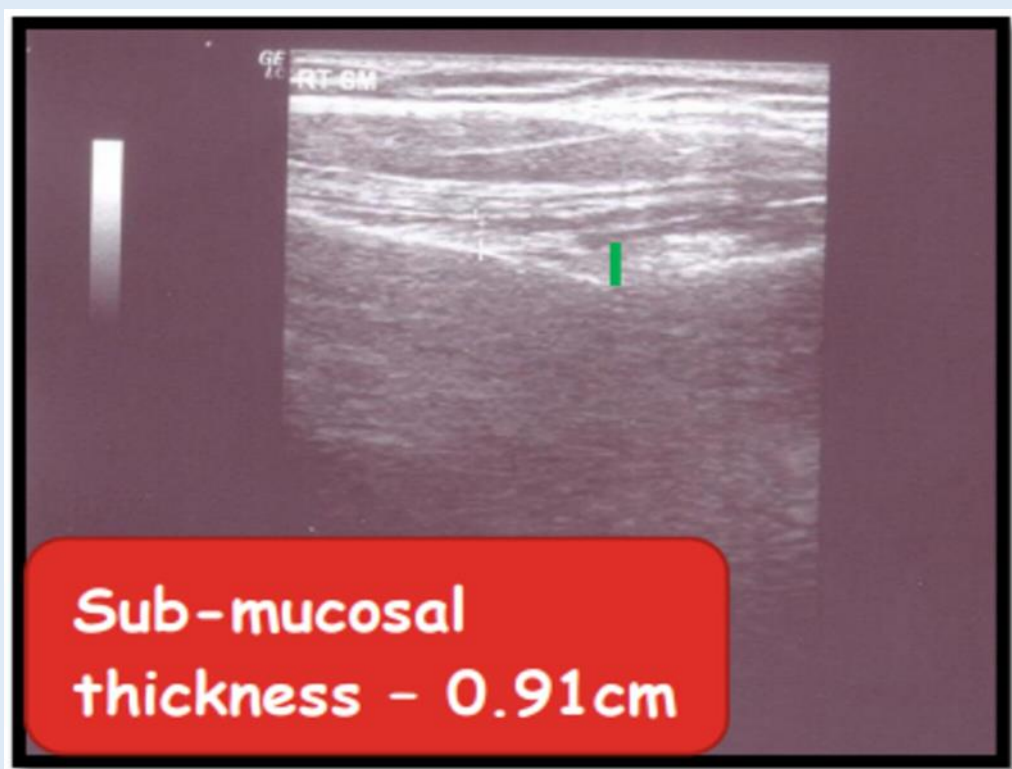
Pre lycopene therapy diagnostic ultrasound.
